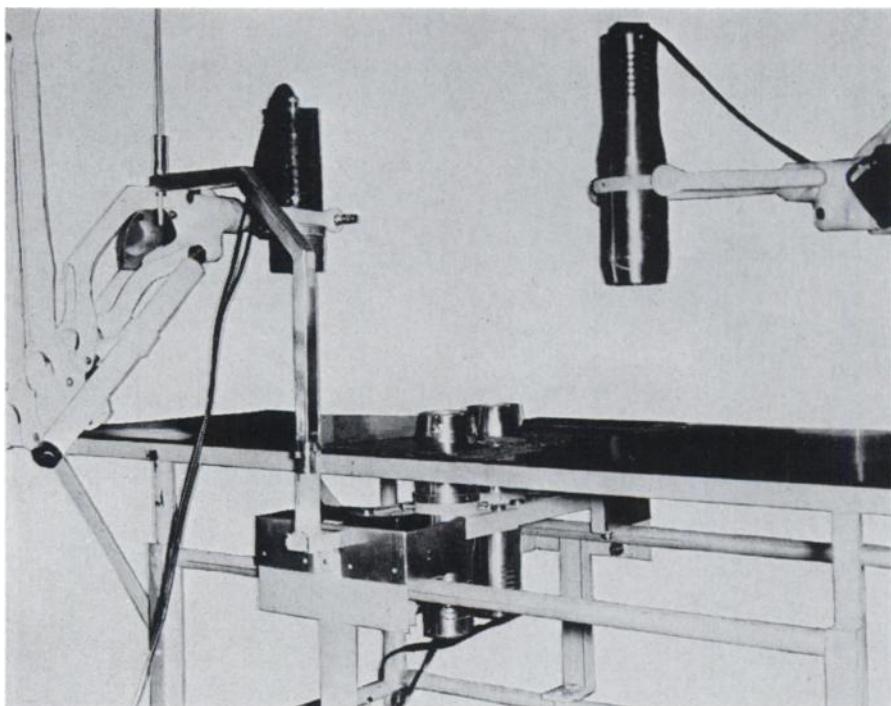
Special table designed for renograms. The patient lies supine. The kidney probes are adjusted over the kidney either by prior x-ray localization of kidneys or by minimal tracer dose administered just prior to renogram study. A third probe is placed over the urinary bladder and the fourth probe is placed over the temperoparietal region of the skull (by present techniques) or over the heart by former techniques. Each probe is balanced and calibrated. The recordings from each probe are connected to a tape recorder and ink writing rectilinear chart recorder. The constant infusion stand is also incorporated as part of the table (on left).
